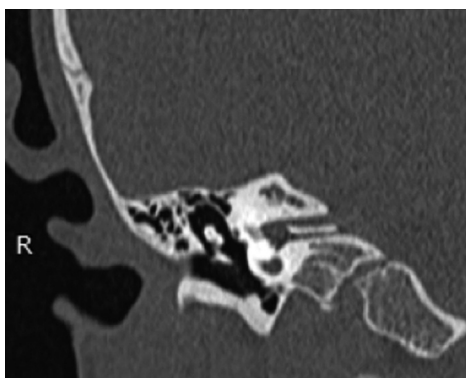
HRCT temporal bone, coronal sections, bone window shows duplicated internal acoustic canal.
